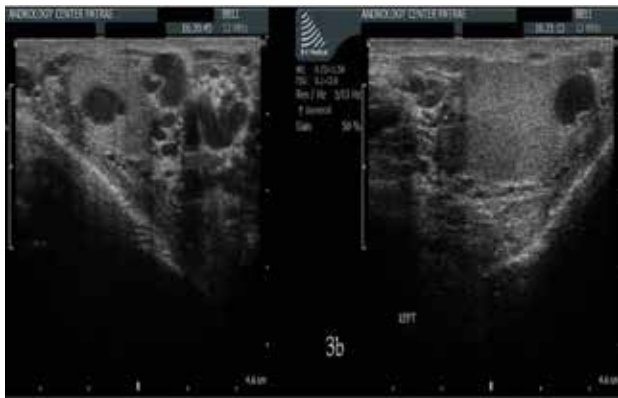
3a) Gray scale scrotal ultrasound confirmed the palpable varicose veins of the gubernaculum in the left testicle; a cystic structure in the lower pole was also found. 3b) The cystic-like structure in the lower pole of left testicle, giving the impression of an intratesticular, subcapsular cyst
